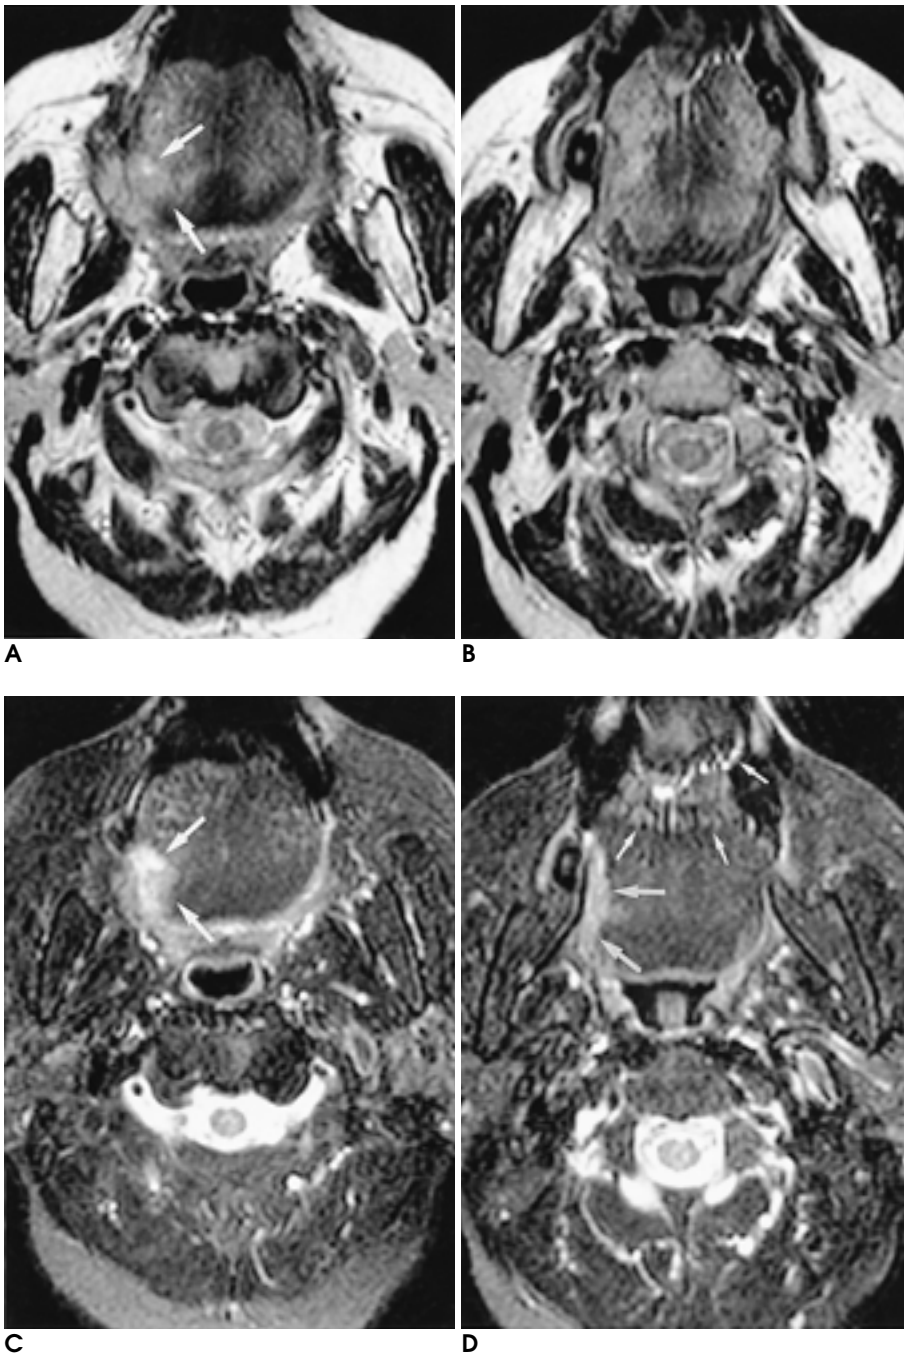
Case 6. A 66- year-old woman with tongue cancer. Although axial fast spin-echo T2-weighted image at level of the upper tongue (A) shows a focal, slightly hyperintense lesion (large arrows) at the right side of the mobile tongue, it cannot be identified on axial image at lower level of the tongue (B). In contrast, axial fat-suppressed fast spin-echo T2-weighted images at level of the upper (C) and lower tongue (D) clearly shows a hyperintense lesion (large arrows). Fat suppressed fast spin-echo T2-weighted image was superior to fast spin-echo T2-weighted image in clearly demonstrating the extent of tumor. Note high signals (small arrows in D) on fat-suppressed fast spin-echo T2-weighted image due to inadequate fat-suppression resulting from the ferromagnetic susceptibility artifact of dental reconstruction.
